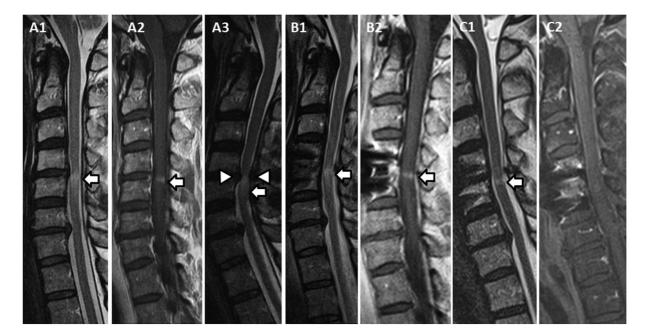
MRI features of cervical spondylotic myelopathy with enhancement. Sagittal T2-weighted (A1, A3, B1, C1) and post-gadolinium T1-weighted (A2, B2, C2) cervical spine MRIs preoperatively (A), postoperatively at 3 months (B), and postoperatively at 12 months (C). A preoperative MRI reveals a short T2-hyperintense lesion (A1, arrow) with an accompanying pancake-like transverse band of enhancement (A2, arrow) with moderate spondylotic changes without obvious compression in the neutral position. MRI undertaken with the neck extended reveals severe spinal cord compression (A3, arrow) from spondylotic changes (A3, arrowheads). Subsequent postoperative MRIs reveal persistent T2-signal abnormality (B1, arrow) and enhancement (B2, arrow) 3 months after surgery with less residual T2-signal (C1, arrow) and no enhancement (C2) at 12 months postoperatively.
